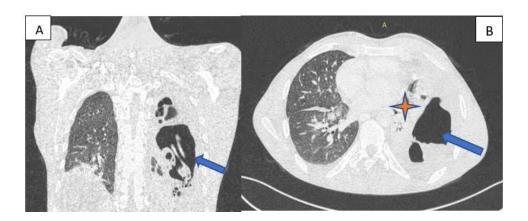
Coronal (A) and Axial (B) chest CT image showing a large loculated hydro-aeric pleural effusion (measuring 77 \times 190 \times 87 mm) occupying the left pleural cavity (blue arrow), associated with a band of passive atelectasis causing near-complete collapse of the adjacent left lung (orange star).
